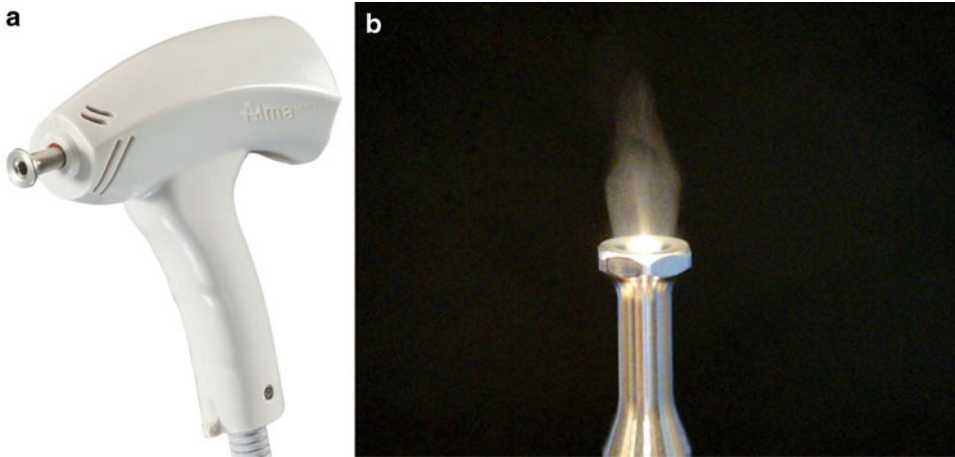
A low-frequency (kHz) ultrasound-assisted drug delivery technology (IMPACT™). The ultrasound applicator (a) handpiece and its sonotrode (b)
